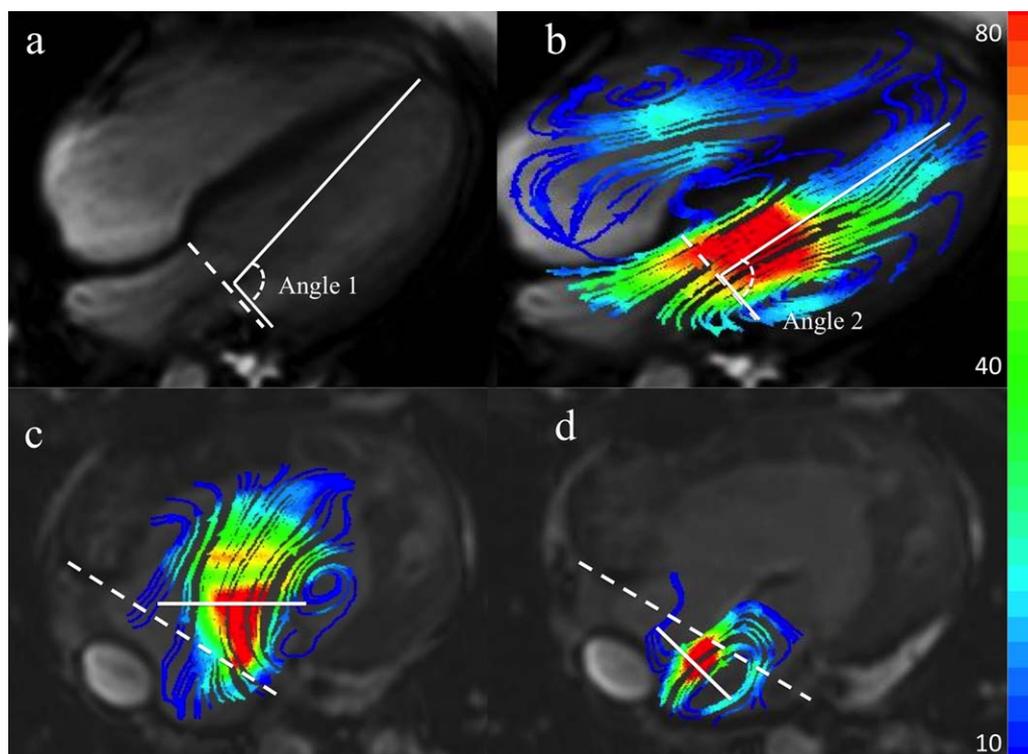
MRI 4D flow with streamline visualization. (A) Healthy volunteer four-chamber view. Angle between long-axis and annulus (angle 1) where annulus (dashed line) was manually identified as the lateral and septal attachment of left AV valve, and long axis as the line through the middle of annulus to the ventricular apex. (B) Healthy volunteer four-chamber view with streamline visualization by velocity encoding (color scale in cm/s). Angle between annulus and peak inflow velocity at E peak (angle 2). (C) A patient with functional univentricular heart, two-chamber view with streamline visualization at diastole phase of cardiac cycle. Positioning of the reformat plane is shown at peak inflow velocity (PIV)-level, angulated perpendicular to the inflow direction (solid line). (D) Same patient during systole of cardiac cycle. Regurgitation jet was observed at the AV valve, and reformat plane was placed perpendicular to the regurgitation jet. [Color figure can be viewed at wileyonlinelibrary.com]
